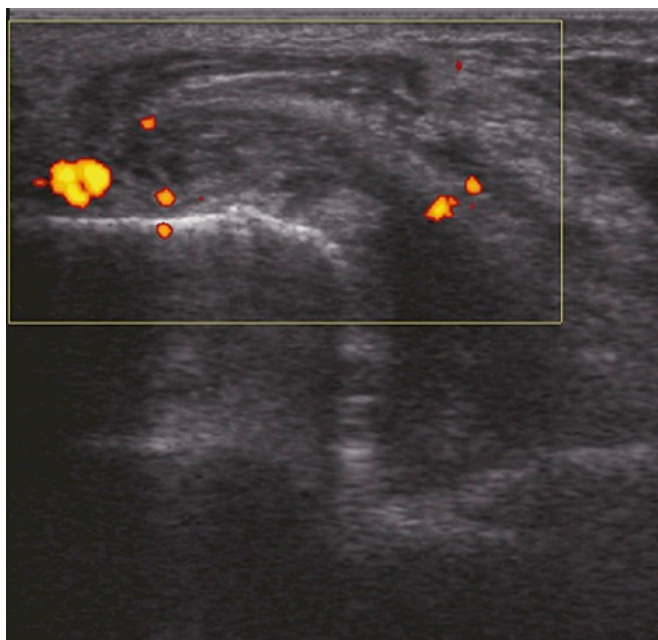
Ultrasound shows elbow synovitis in the posterior midsagittal view.
